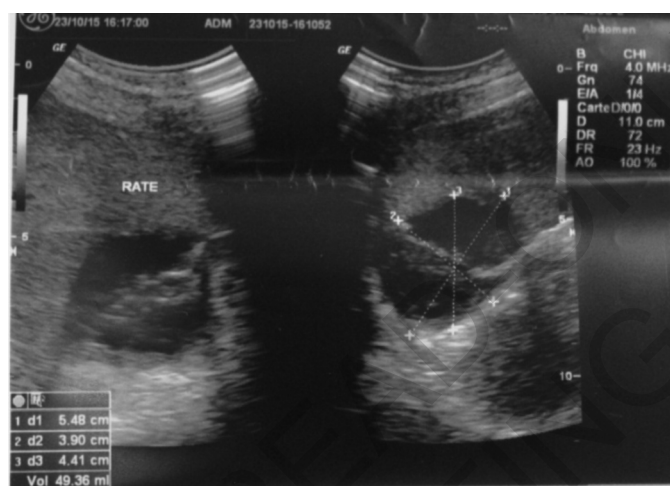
Ultrasonography findings five months later
